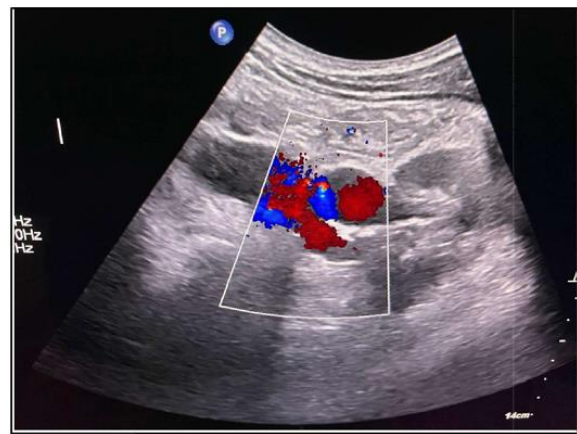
Doppler showing flow in the shunt
